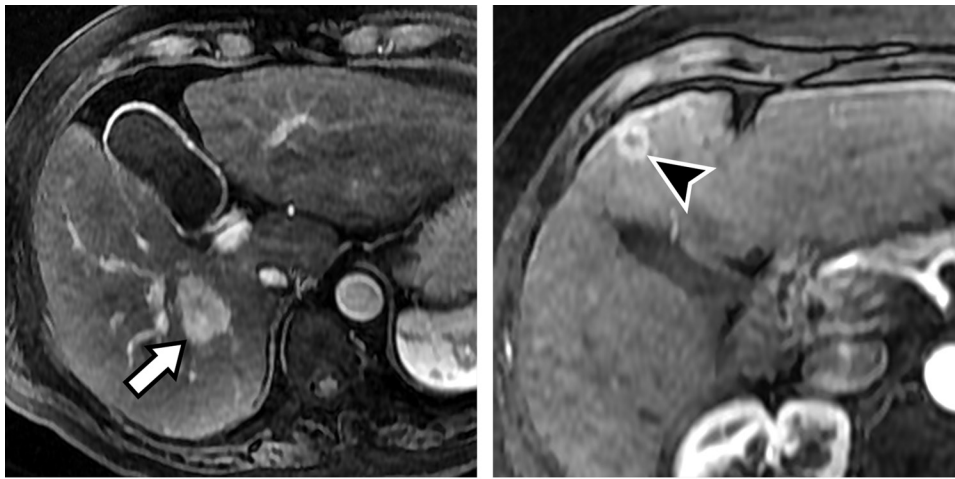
APHE in a 70-year-old man with a lesion categorized as LR-5 (definitely HCC) (a) and a 58-year-old woman with a lesion categorized as LR-M (probably or definitely malignant) (b). Axial T1-weighted late arterial phase MR images show non-rimlike APHE (arrow in a) versus rim APHE (arrowhead in b).
